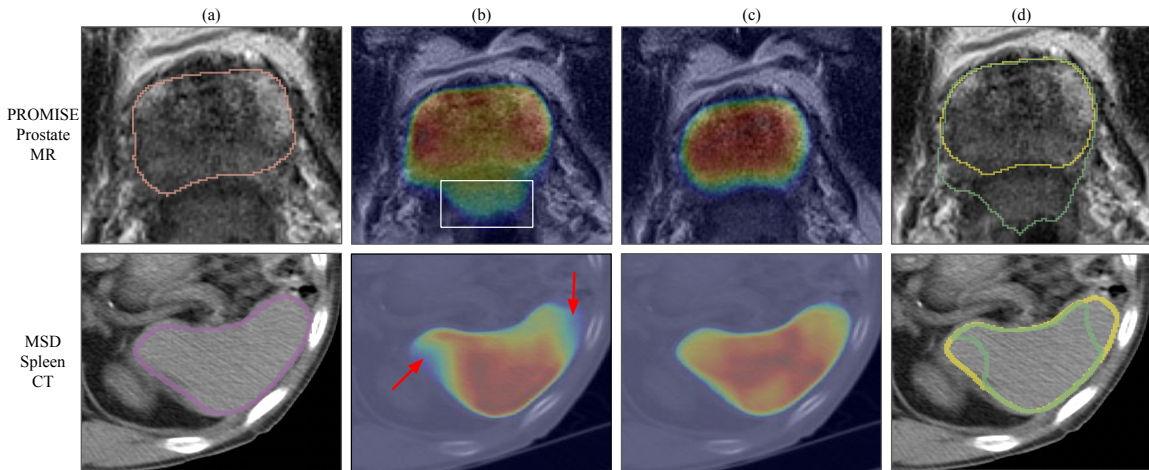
Qualitative comparison of attention maps for nnU-Net and IB-nnU-Net. (a) Raw MR and CT images with ground-truth annotations. (b) Attention maps of nnU-Net showing spurious and missed regions. (c) Attention maps of IB-nnU-Net showing robust segmentation performances. (d) Final predictions: green and yellow contours denote nnU-Net and IB-nnU-Net outputs, respectively.
